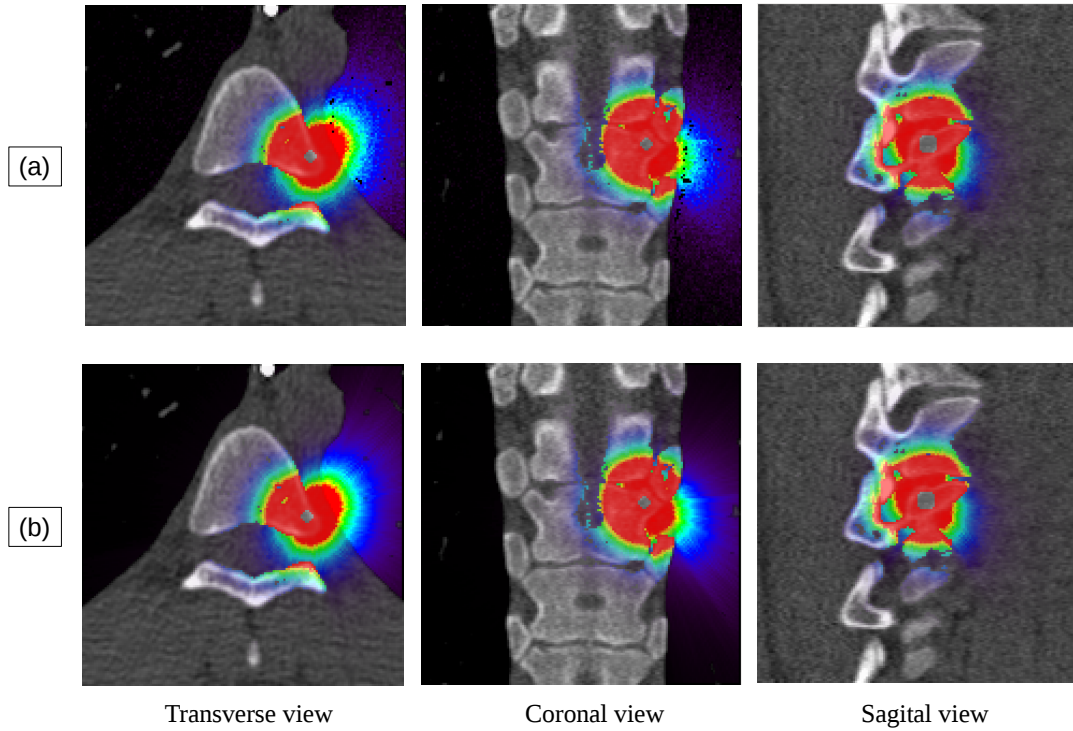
Dose distribution on a CT representing a Kypho-IORT treatment with (a) penEasy, (b) HMC
